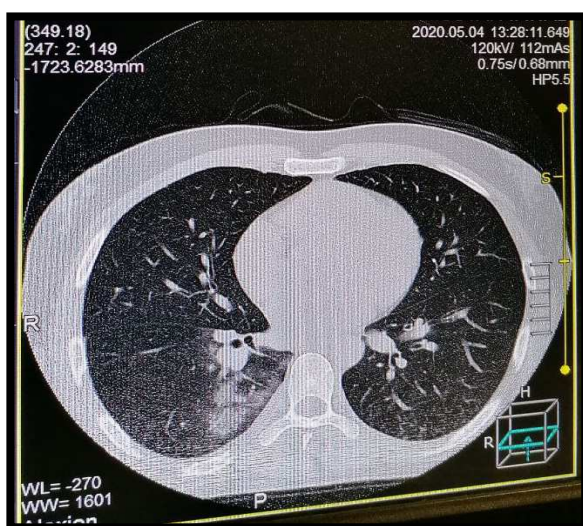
Noncontrast chest HRCT images in a 46-year-old man with mild COVID-19.
